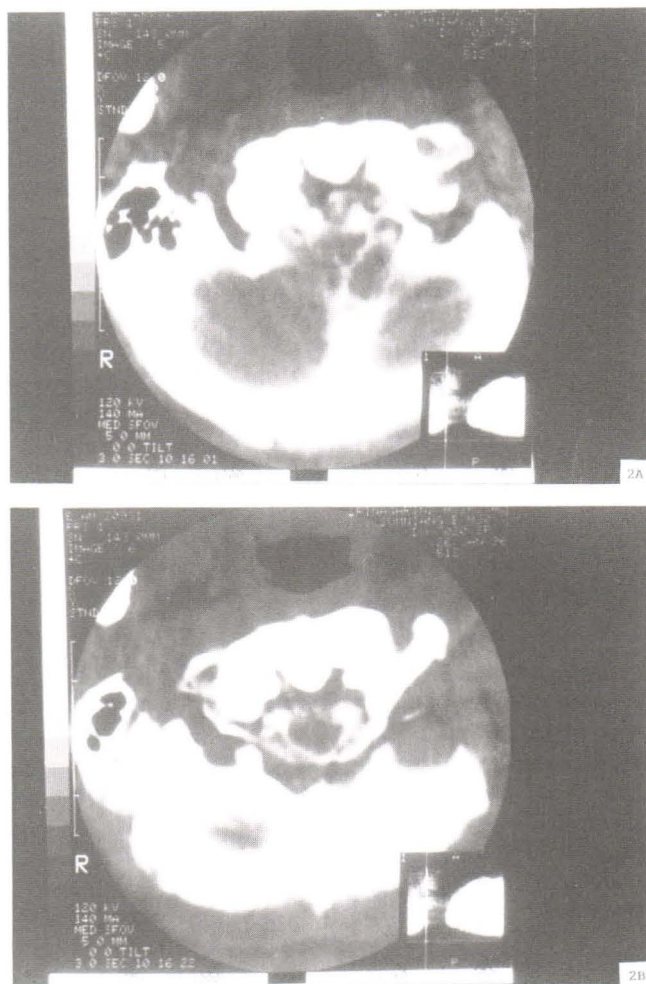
A, B. CT-myelogram show upward displacement of C1 with overriding at anterior lip of foramen magnum over dens and compression on medulla.
